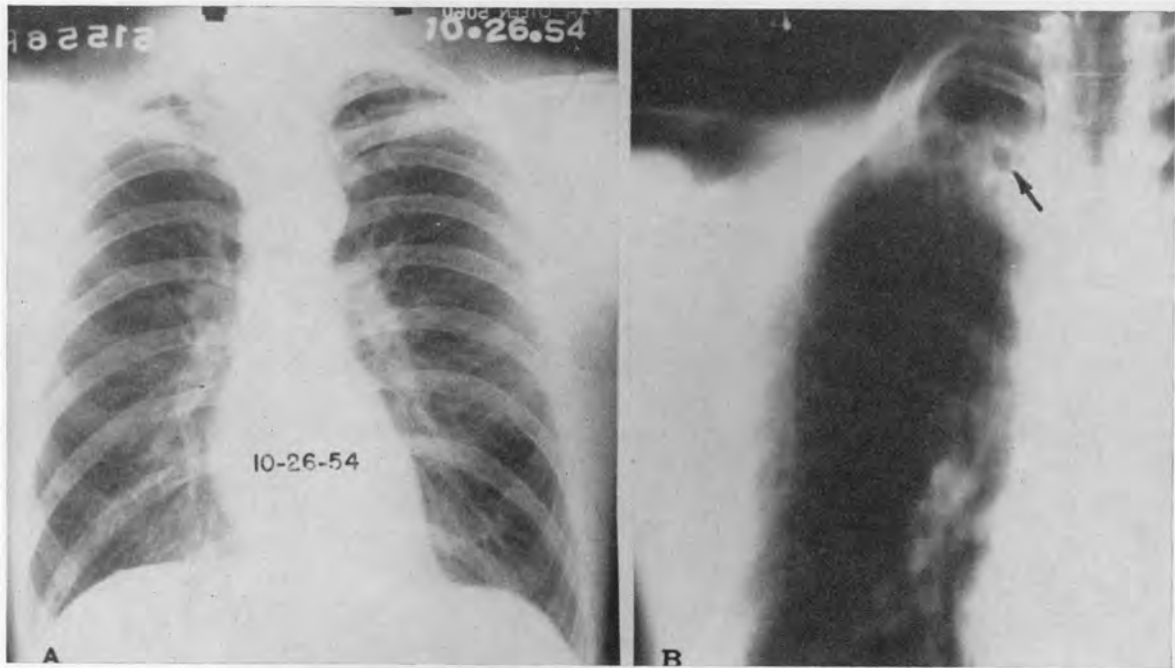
Roentgenogram of the Chest on Admission (A) in Case 1, Showing Fibrocavitary Disease in the Right Apex, and Planigram (B), Showing the Cavity.
